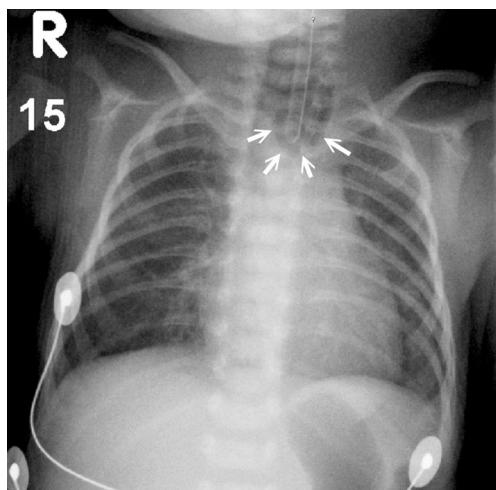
Air contrast radiograph of the upper pouch (arrows). Also note air in stomach, indicating the presence of a distal tracheoesophageal fistula
